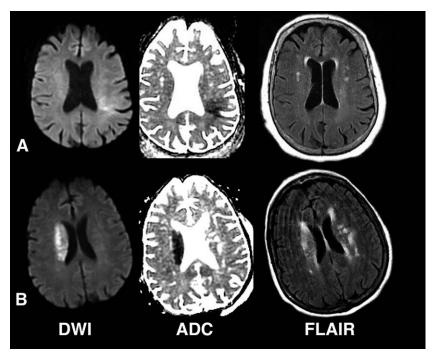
Examples of enrolled and nonenrolled subjects. (A) Magnetic resonance imaging (MRI) from an enrolled subject obtained approximately 3 hours after symptom discovery in a 77-year-old female presenting with unwitnessed symptom onset and right-sided weakness, numbness, and aphasia. Her National Institutes of Health Stroke Scale (NIHSS) score was 10. (B) MRI from a nonenrolled subject obtained approximately 1.25 hours after symptom discovery in a 78-year-old female presenting with unwitnessed symptom onset and left-sided weakness, last known to be well the night before. Her NIHSS score was 15. ADC = apparent diffusion coefficient; DWI = diffusion-weighted imaging; FLAIR = fluid-attenuated inversion recovery.
